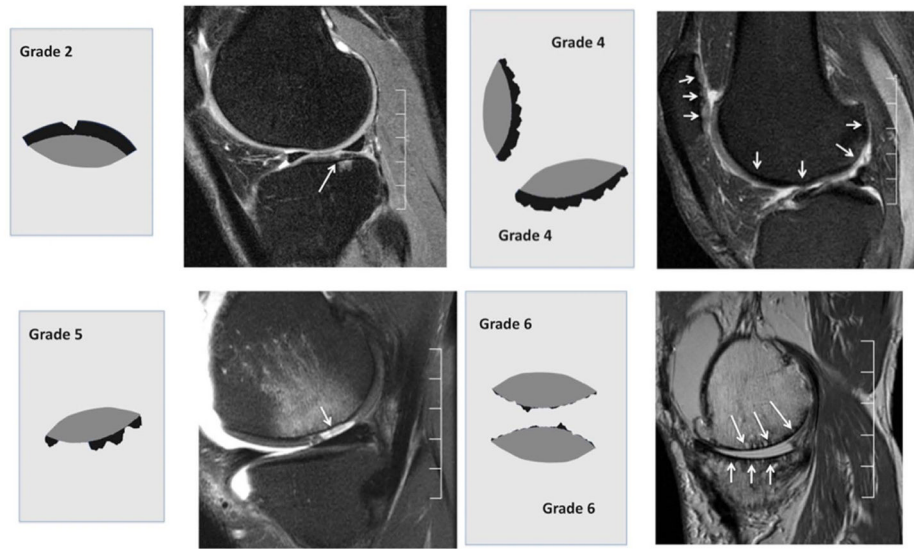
Representative MR images with different stages of cartilage lesions and the corresponding WORMS scores.
